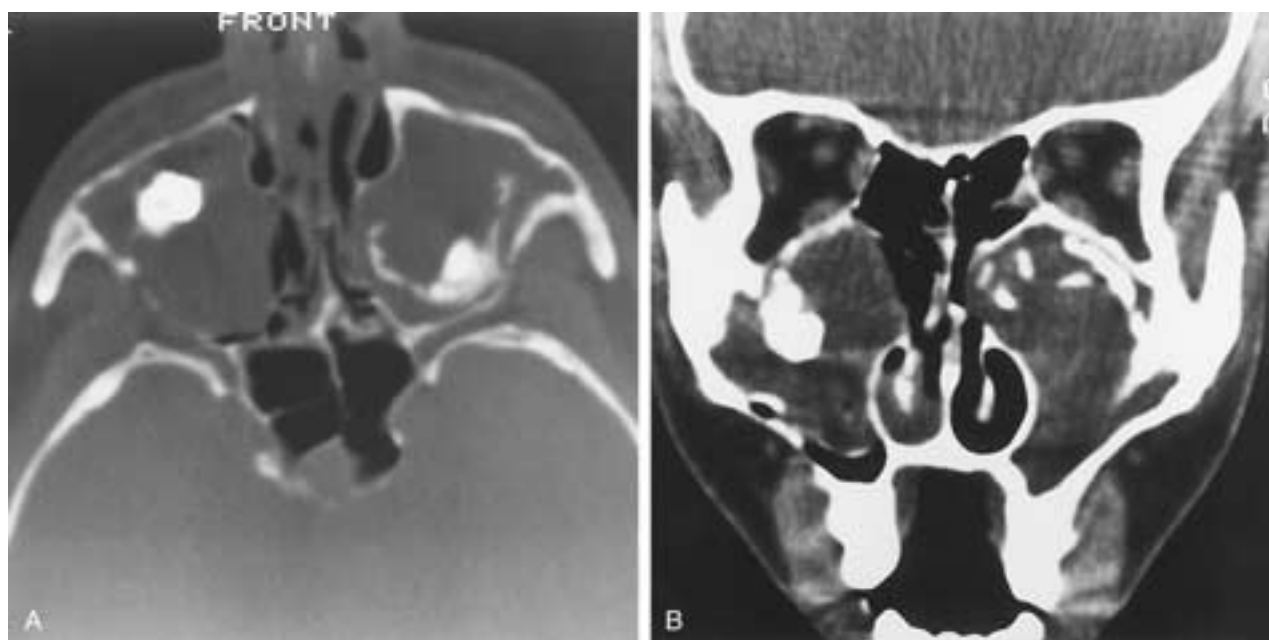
Bilateral maxillary keratocysts in a patient with the basal cell nevus syndrome. A, Axial CT (bone window setting) through the maxillary antra shows slightly expansile lesions in both antral cavities reflected by a cystic bony rim in the left antral cavity and some lateral expansion and thinning of the wall of the right antrum. Note the displaced teeth on the left and right within the cystic lesions. B, Coronal CT (soft-tissue window setting) demonstrates bilateral cystic lesions in the maxillary antra, with part of a thin rim of surrounding bone seen in the left antrum. Note the displaced tooth in the upper part of the right antral cavity and the low attenuation of the cyst contents.
